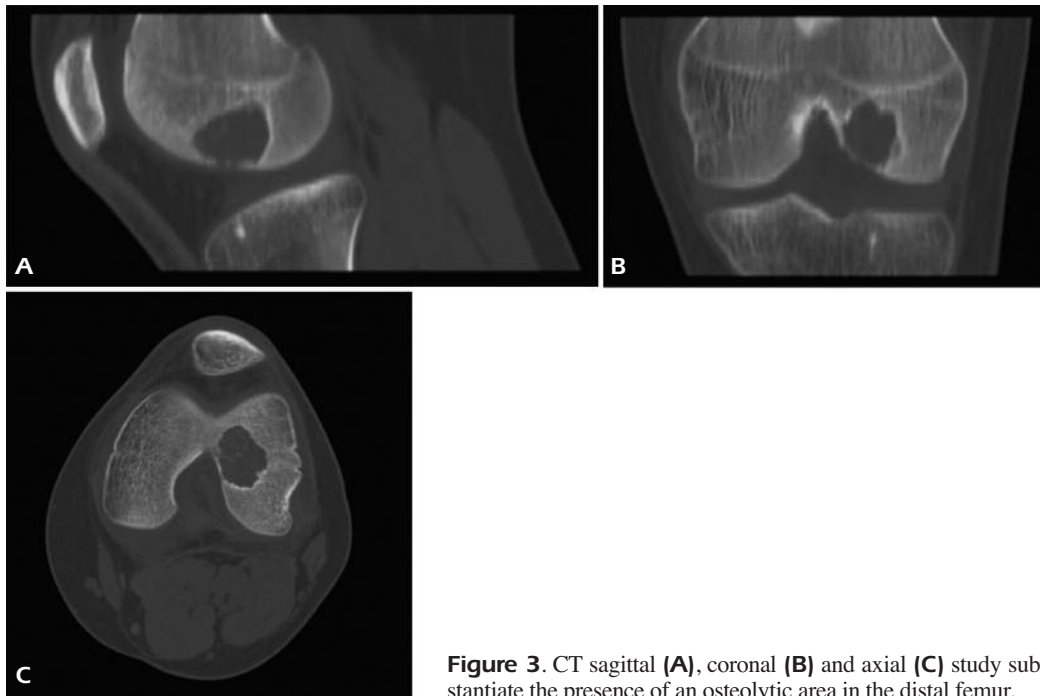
CT sagittal (A), coronal (B) and axial (C) study substantiate the presence of an osteolytic area in the distal femur.
